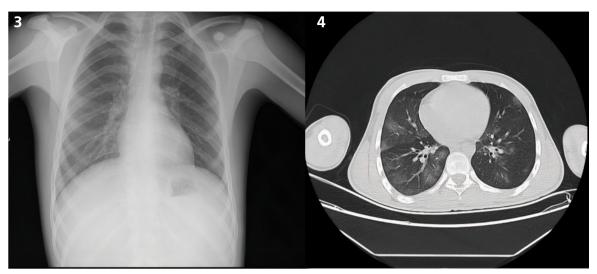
The chest radiography of the patient showed opacities consistent with pneumonic consolidations in the middle and lower zones of both lungs, more in the right lung
